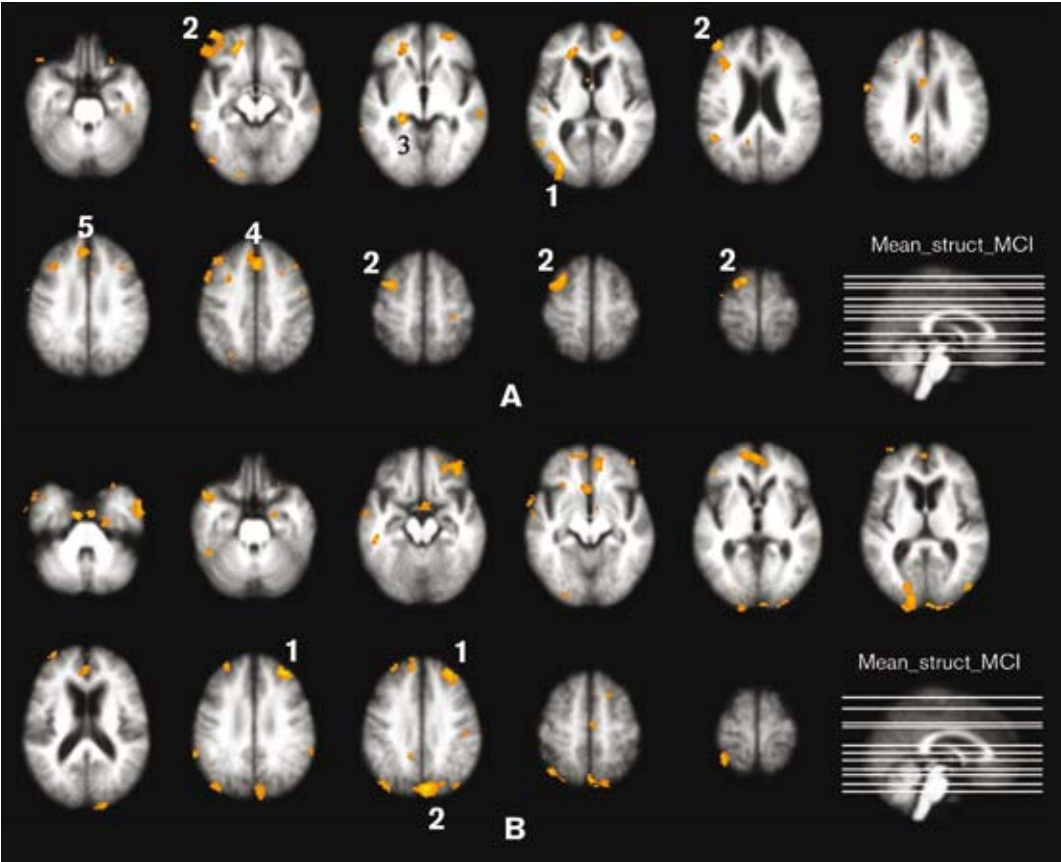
Axial slices showing effects of medication (SS > BL) on activation patterns related to face encoding (A) and working memory performance (B). Left in the image is left in the brain. Threshold for significant brain activation has been lowered to $Z = 2.3$ (uncorrected p) for display purposes. Colour scale extends from $Z = 2.3$ (orange) to $Z = 4.5$ (yellow). Numbered activation blobs are significant at a Z -threshold of 3.1 (uncorrected p). Mean_struct_MCI = average T1-weighted brain of 28 MCI patients. A: 1. Left middle occipital gyrus. 2. Left middle frontal gyrus. 3. Left hippocampus. 4. Right anterior cingulate gyrus. 5. Right middle frontal gyrus. B: 1. Right middle frontal gyrus.; 2. Right precuneus.
